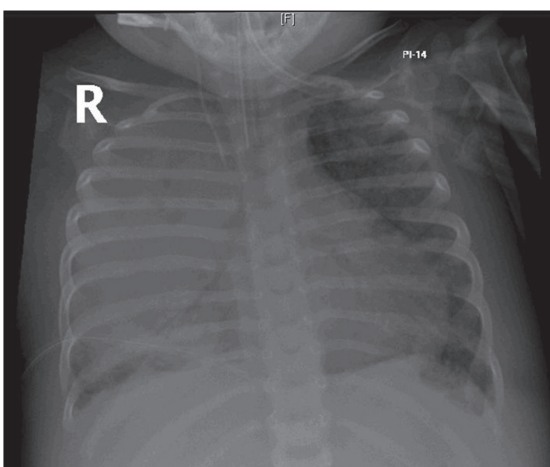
Chest x-ray on day of death.
